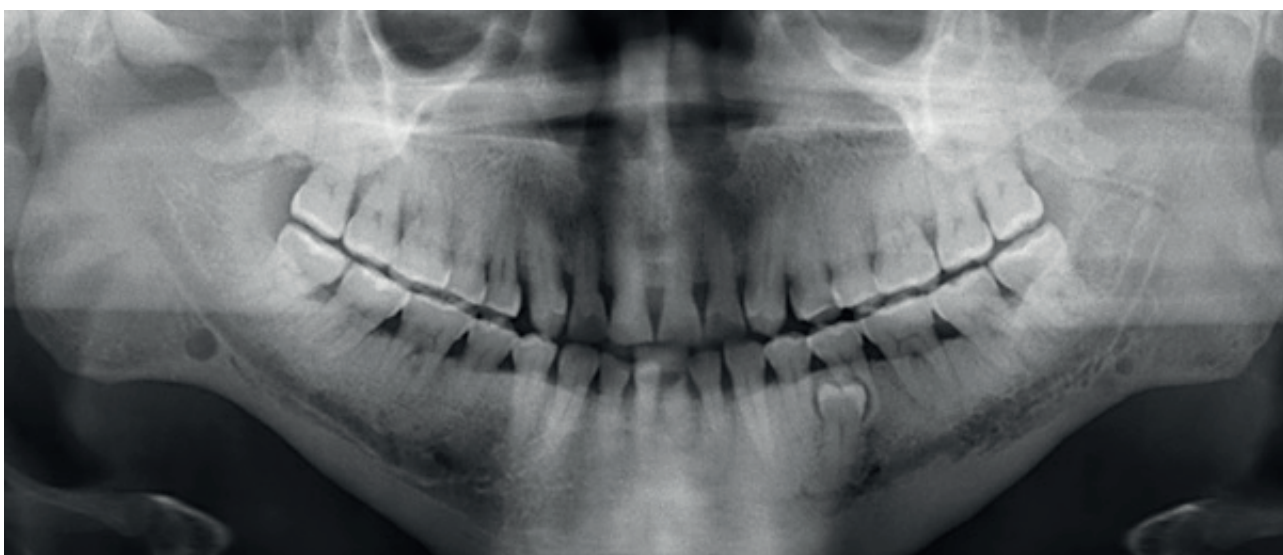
Panoramic radiograph depicting a supernumerary tooth in the premolar region
